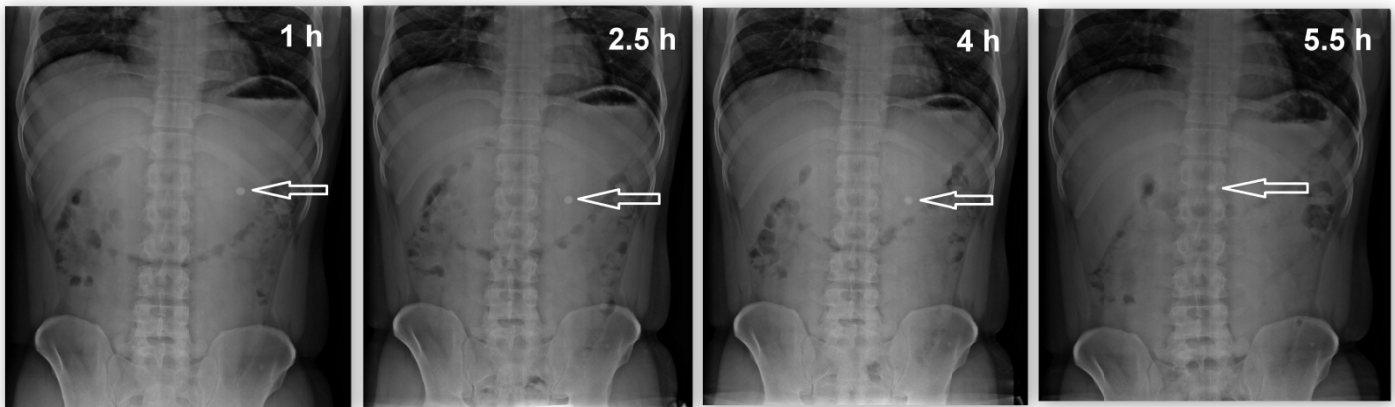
Radiographic images showing the presence of  $\text{BaSO}_4$ -loaded RSFBTsopt in the stomach at different time intervals (the tablet location was pointed out with a circle) of 1 h, 2.5 h, 4 h and 5.5 h.
